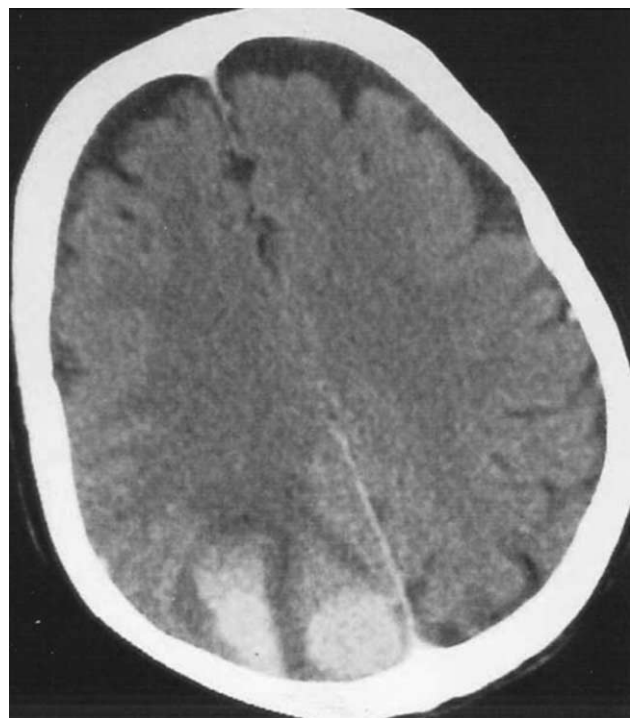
Enhanced CT scan, showing a parasagittal homogenous high-density meningioma and a cortical parietal haematoma.
